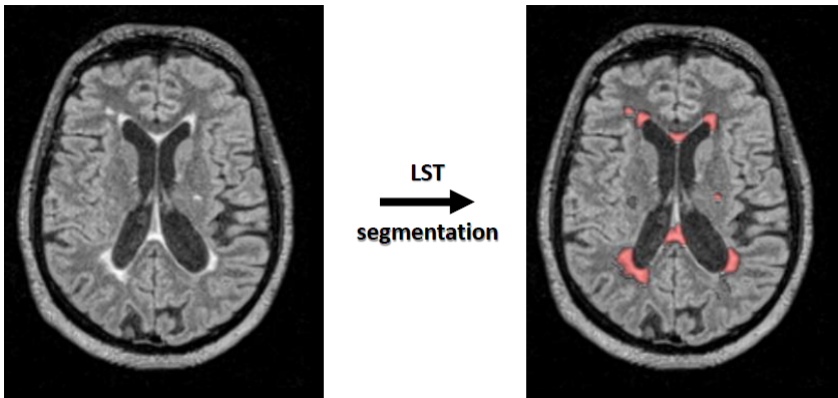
Example of a FLAIR image and the *a priori* lesion mask generated with the LGA algorithm, both in the transverse plane.
